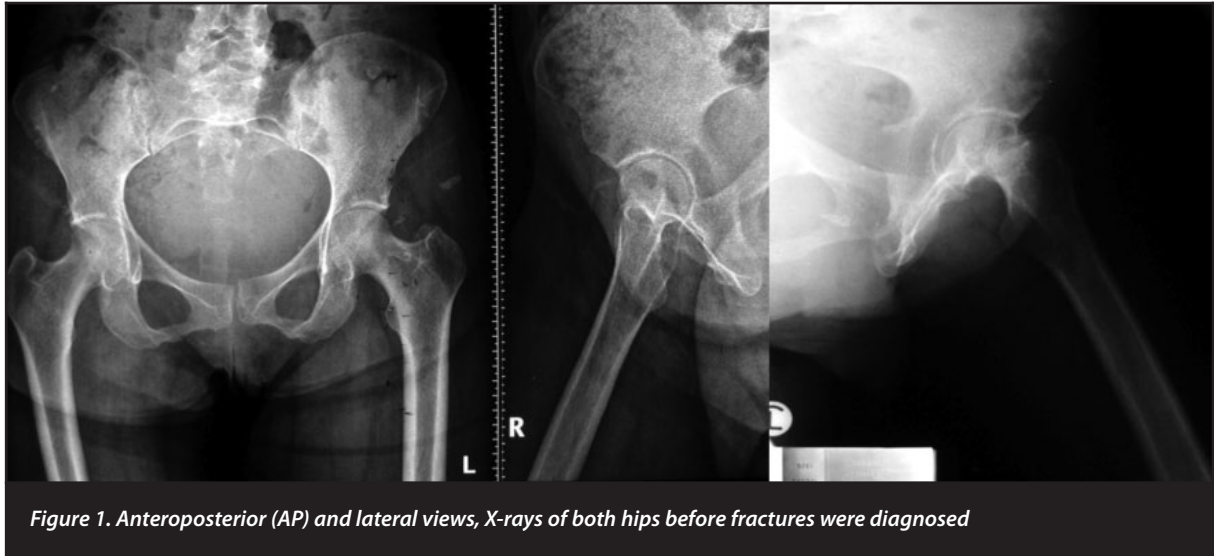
Anteroposterior (AP) and lateral views, X-rays of both hips before fractures were diagnosed
